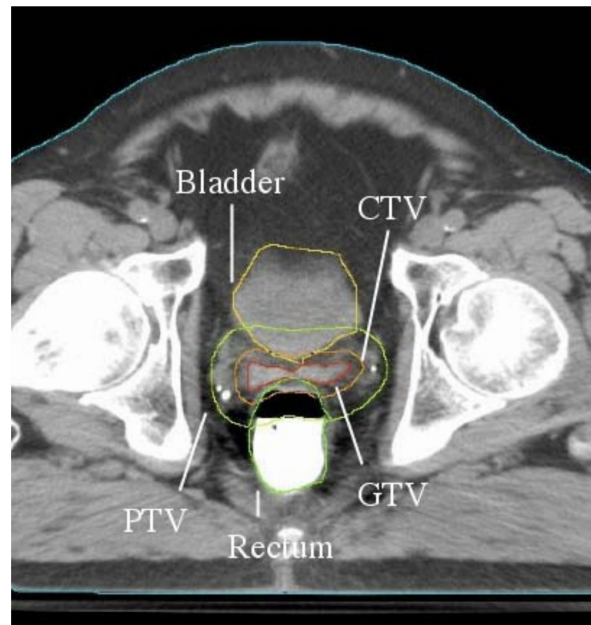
GTV, CTV, and PTV on CT slice for a prostate treatment plan (30)
